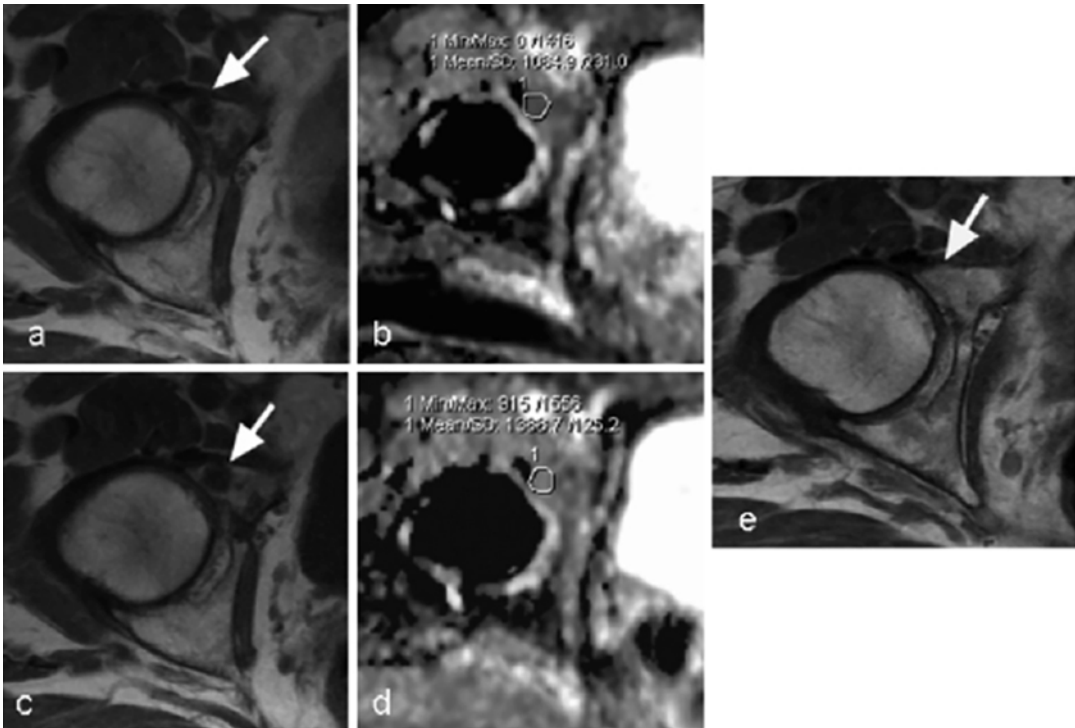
Diffusion-weighted magnetic resonance imaging (MRI) demonstrating disease regression in a patient with prostate cancer and BRCA2 mutation associated with a >50 % decline in PSA. A 63-year-old man with germline BRCA2 mutation and castration-resistant prostate cancer. T1 weighted MRI at the level of the right acetabulum in the pelvis obtained (a) prior to and (c) 3 months after initiating treatment with olaparib showed no substantial change in a 13 mm low-signal intensity
